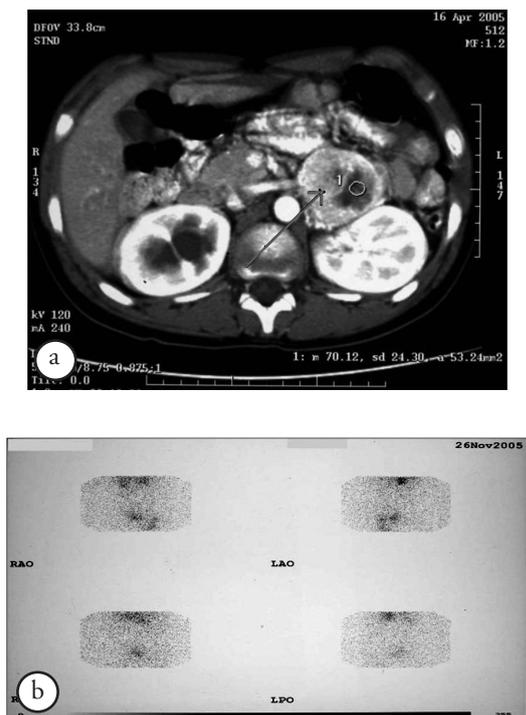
a) Magnetic resonance imaging post contrast showed left adrenal mass. b) Metaiodobenzylguanidine (^{131}I -MIBG) scintigraphy showed increase uptake at adrenal mass indicated pheochromocytoma.
